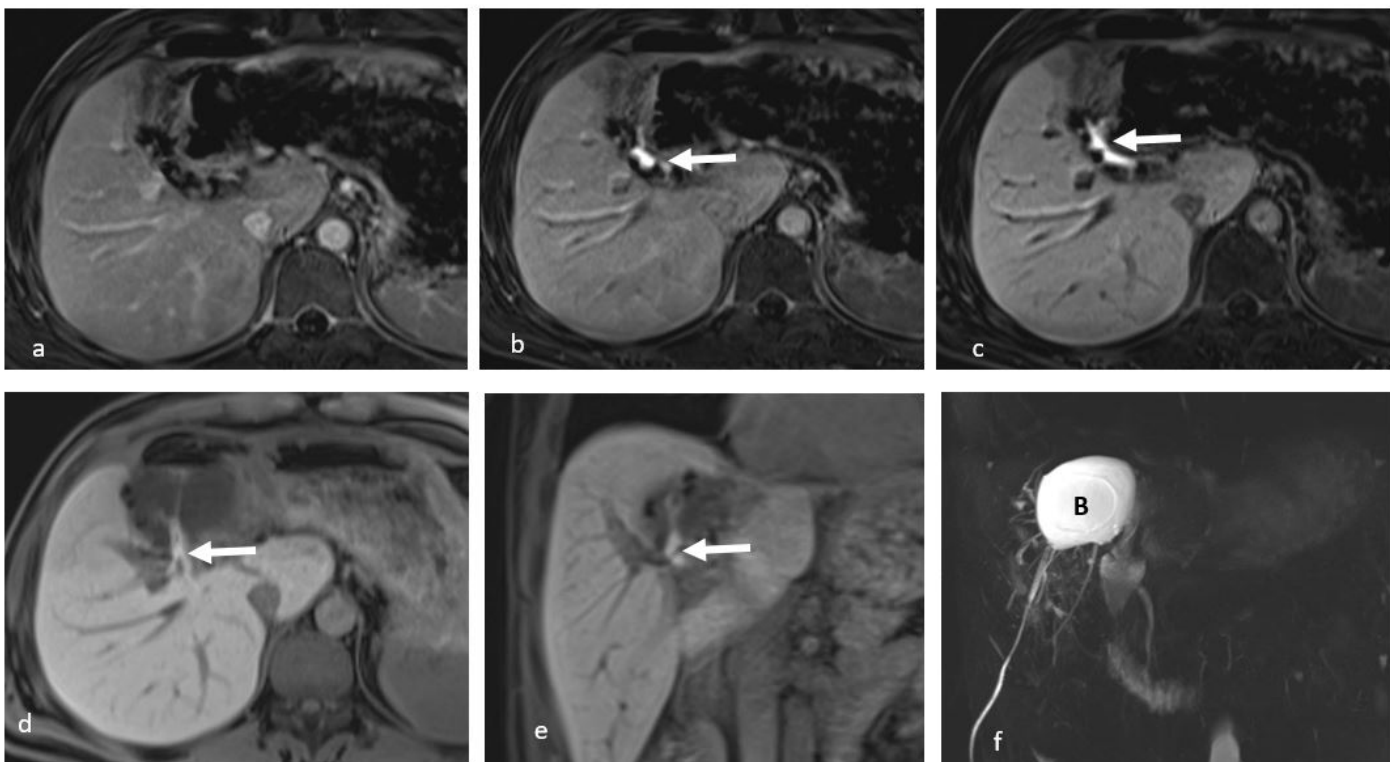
T1-weighted MR images obtained after administration of a hepatocyte-specific contrast agent in a left-lobe donor demonstrate progressive contrast extravasation compatible with active biliary leakage. (a) Equilibrium phase image, (b) 10-minute hepatobiliary phase image, and (c) 30-minute hepatobiliary phase image show increasing contrast accumulation (arrows) adjacent to the hepatic resection margin. (d) Axial and (e) coronal extended delayed hepatobiliary phase images at 120 minutes further confirm contrast leakage (arrows). (f) Coronal maximum-intensity-projection MRCP image demonstrates the corresponding biloma (B) formation and leakage site.
